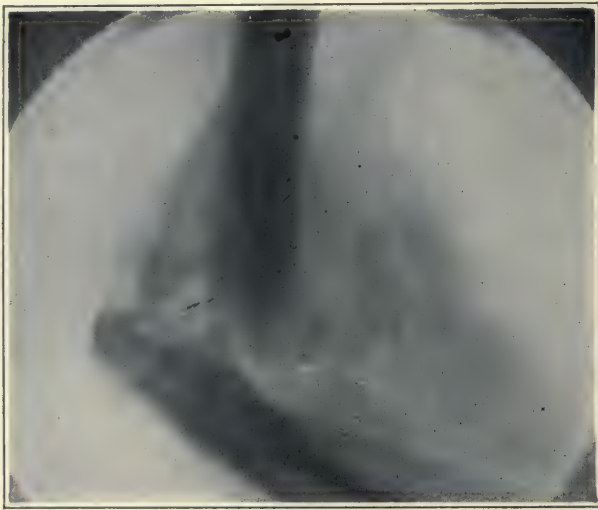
Old Unreduced Posterior Dislocation of Both Bones at the Elbow, Showing Newly Formed Bone Beneath the Stripped-up Periosteum. (Roentgen Department of Lane Hospital, San Francisco.)
